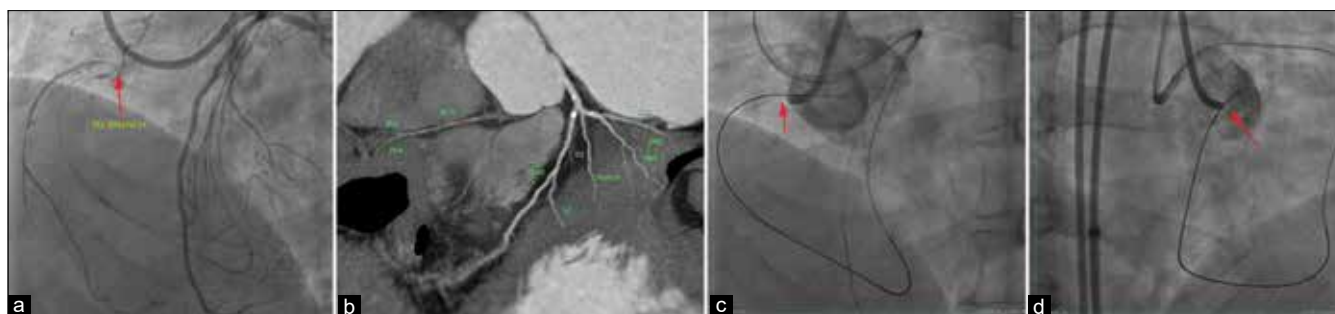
Stumpless ostial RCA CTO. (a and b) Angio and CT image showing short segment ostial RCA CTO and normal origin with perpendicular course of proximal RCA. (c) LAO View: Retrograde Gaia 2 Coursing horizontally towards aorta. (d) RAO view: Retrograde Gaia 2 entering aorta at mid right coronary sinus. RCA: Right coronary artery, CTO: Chronic total occlusion
